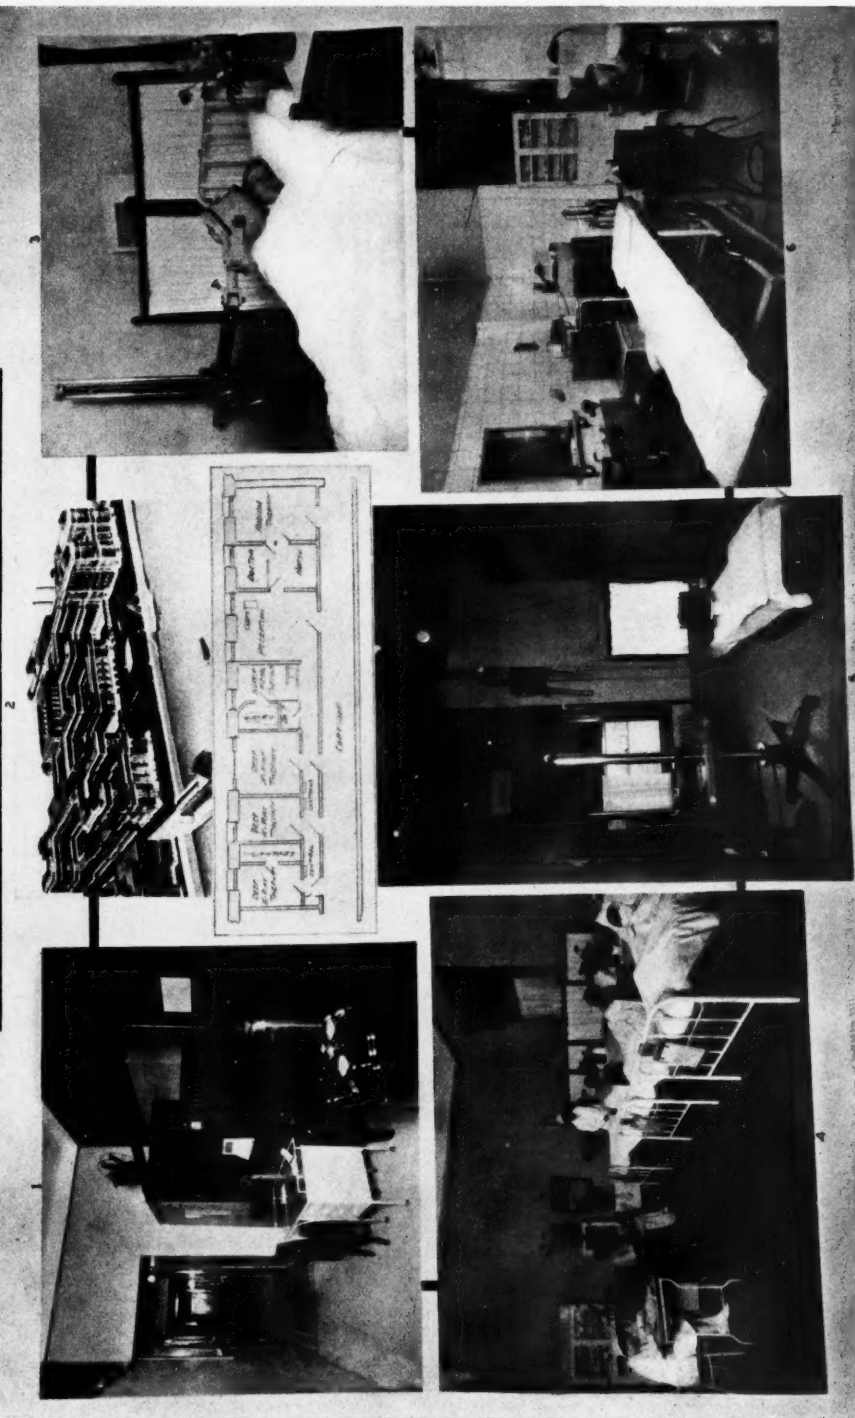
(1) X-ray Therapy Department. (2) Bellevue Hospital; plan of Radiation Unit. (3) Portable Radium Pack. (4) Radium Ward. (5) X-ray Therapy Treatment Room. (6) Operating and Radium Treatment Room.
